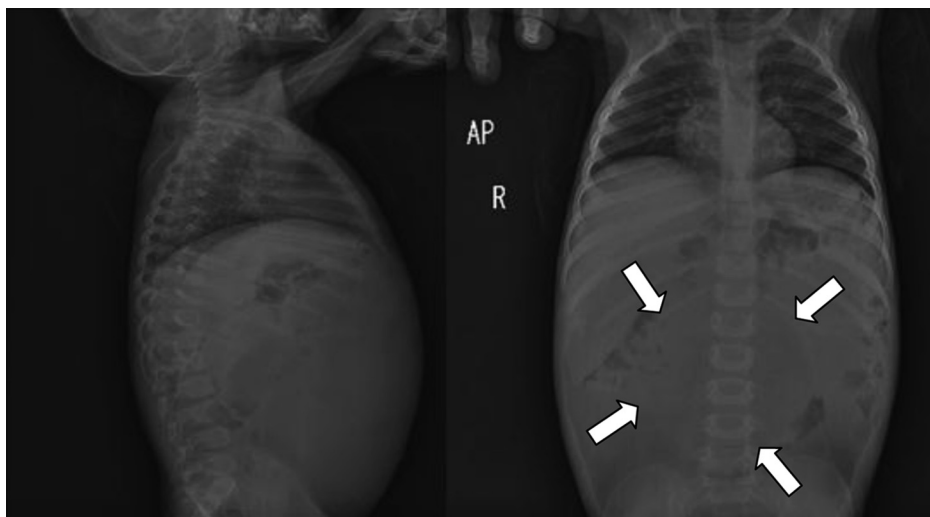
Abdominal radiography demonstrated a large soft tissue mass in the abdomen distinct from the spleen and the liver.
